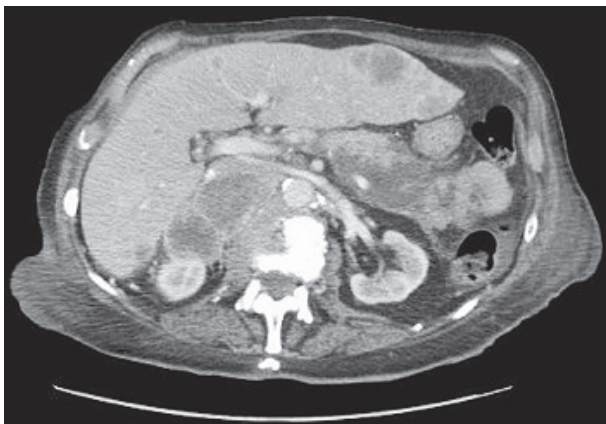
Computed tomography abdomen demonstrated cystic secondary deposits in the head and tail of pancreas.
